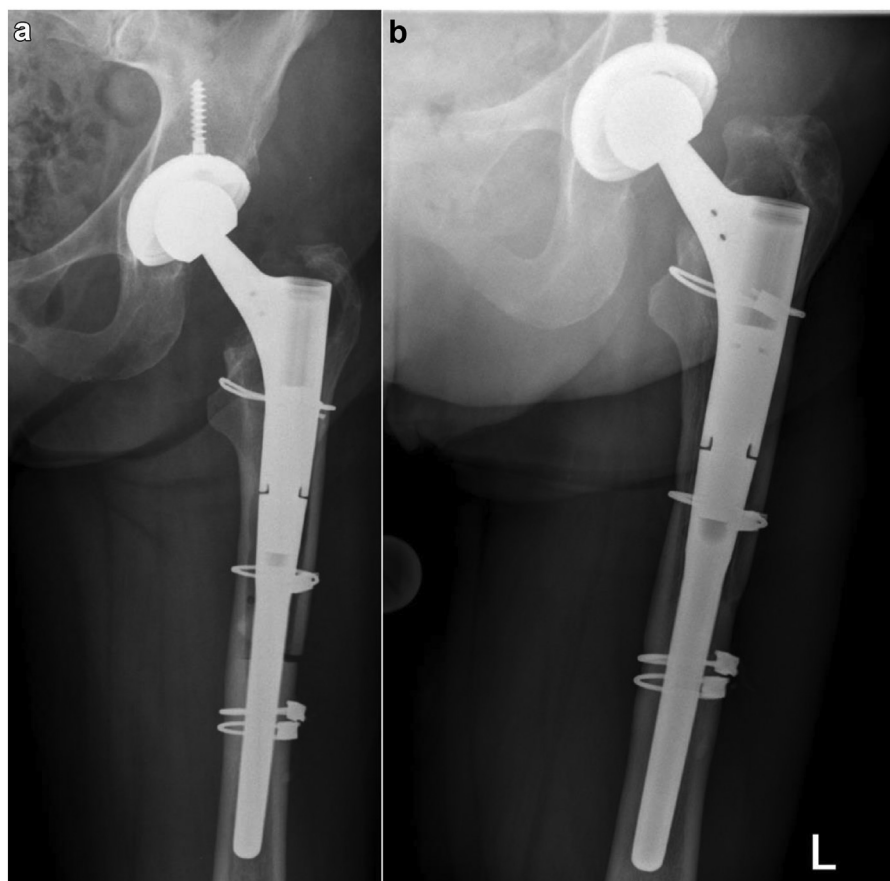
Radiographs taken postoperatively (a) and at a follow-up visit (b) showing stem subsidence.
